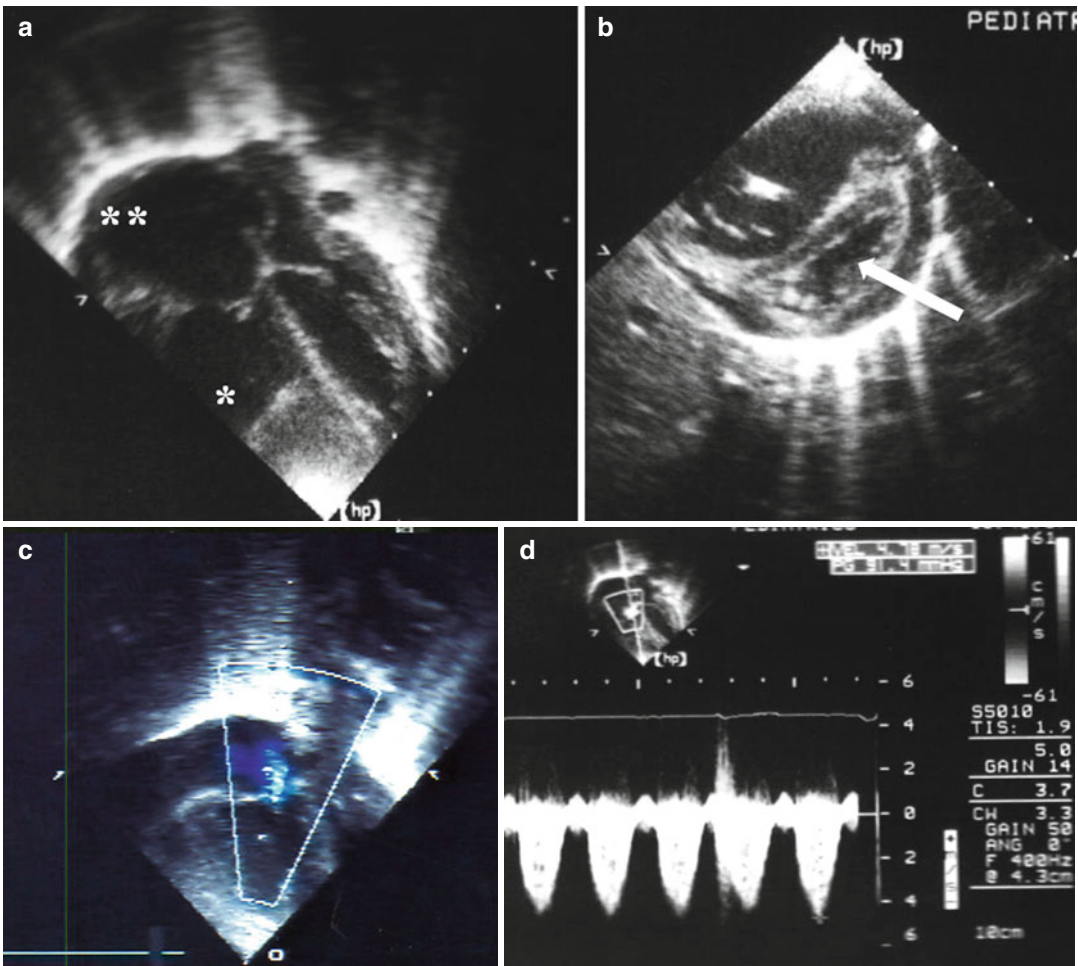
Echocardiographic signs in a case of pulmonary hypertension: (a) severe enlargement of the right ventricle (*asterisk*) and atrium (*double asterisk*); (b) hypertrophy of the right ventricle with shift of the ventricular septum (*arrow*) toward the left ventricle; (c) blood regurgitation
